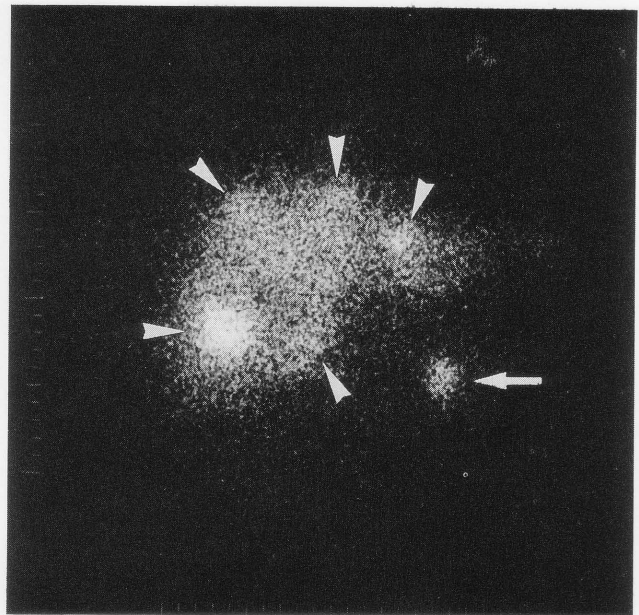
^{131}I -MIBG scintigram after administration of a therapeutic dose in patient 4. High uptake can be seen by metastatic lesions in the liver (arrowheads) and the splenic hilum (arrow).
